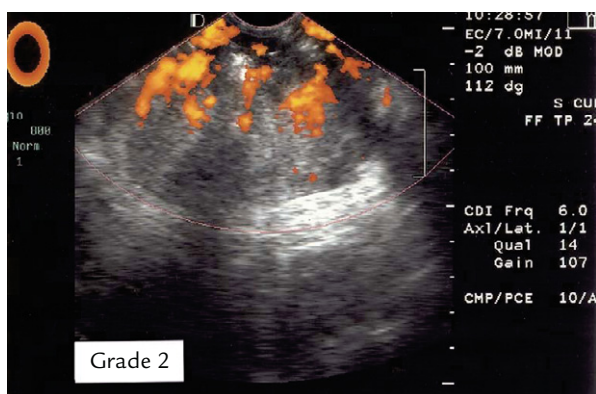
Power Doppler ultrasound shows grade 2 vascularity ($25\% < \text{vascular ratio} < 50\%$) within the tumor.
